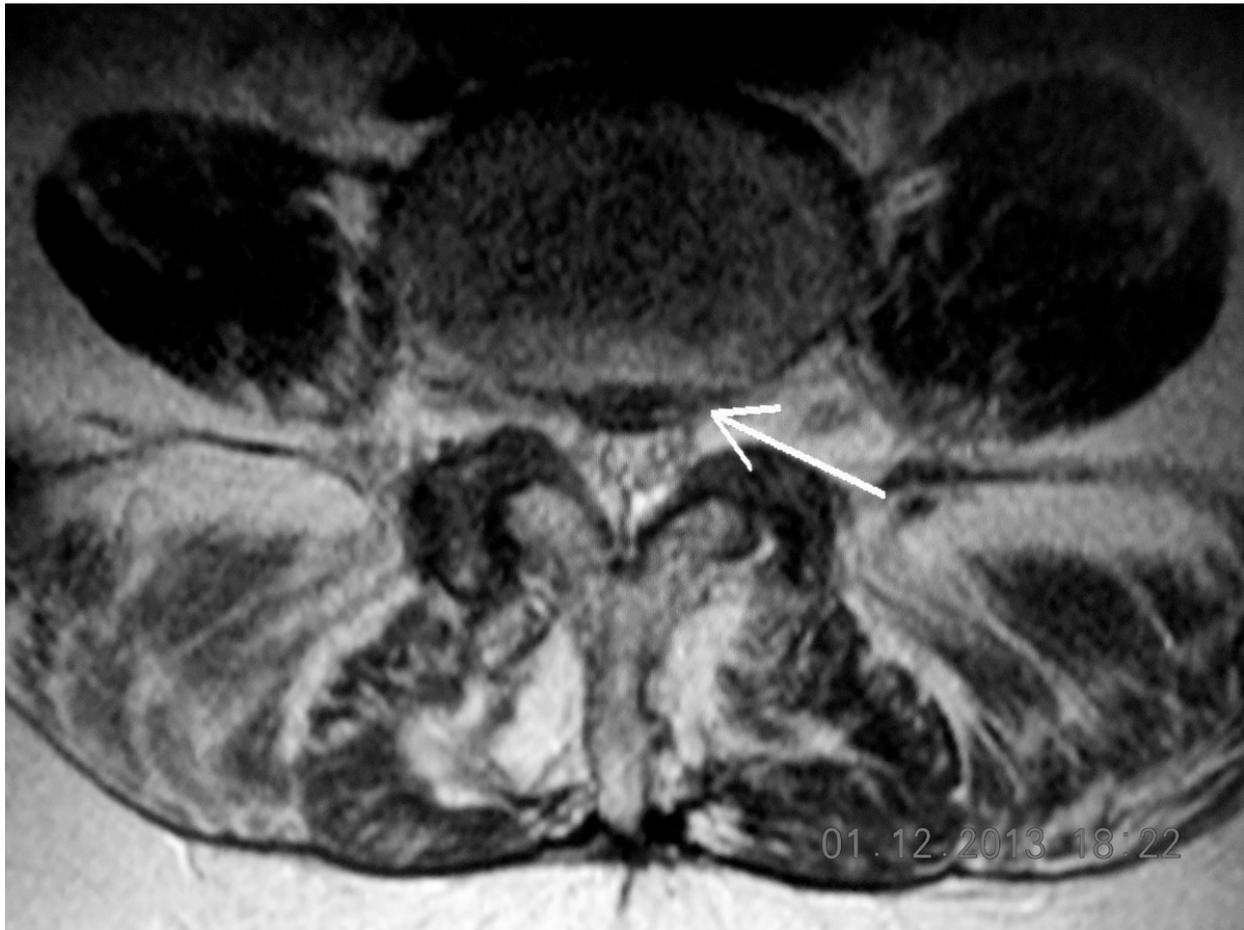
Axial T2 Weighted Lumbar Spine MRI image showing L3/L4 Central Focal Disc Protrusion With Moderate Canal Stenosis
